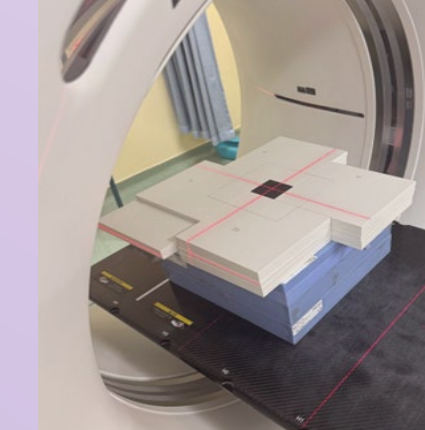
Jig for CT and dosimetry assessment of 3D printed cubes
